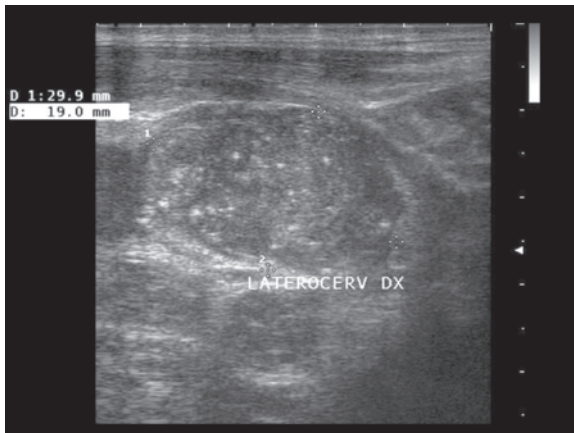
b Metastatic lymphadenopathy of the neck from oropharyngeal carcinoma. Large nodal mass anteriorly displacing the sternocleidomastoid muscle (a). Moderate capsular and irregularly distributed vascularity at directional PD (b). The poor vascular signal in the deep portion of the lesion is due to limited sampling ability of the Doppler signal with the transmit frequency used by the superficial transducer
